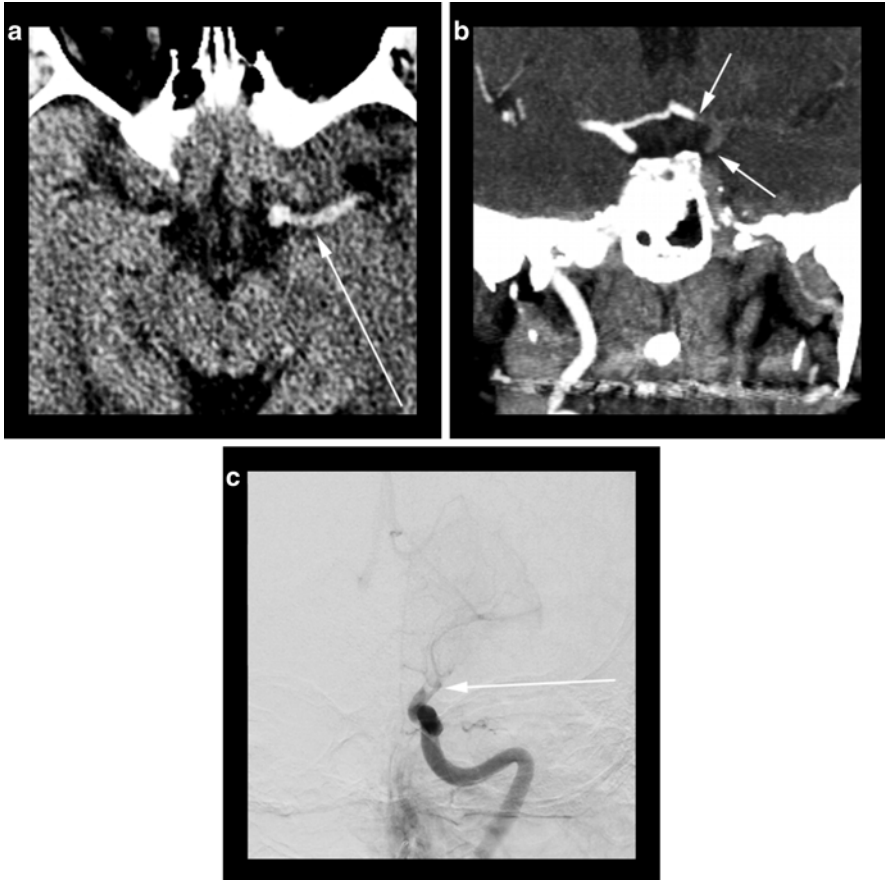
(a) An axial noncontrast CT image of the head reveals an asymmetric hyperdense left internal carotid artery terminus and left proximal middle cerebral artery (*arrow*). (b) A coronal CTA MIP image reveals nonopacification of the left internal carotid artery terminus (*right arrow*), proximal left anterior cerebral artery (*left arrow*) and the left proximal middle cerebral artery. (c) A frontal projection digital subtraction angiogram with injection of the left internal carotid artery corroborates findings from the CTA (*arrow*)
